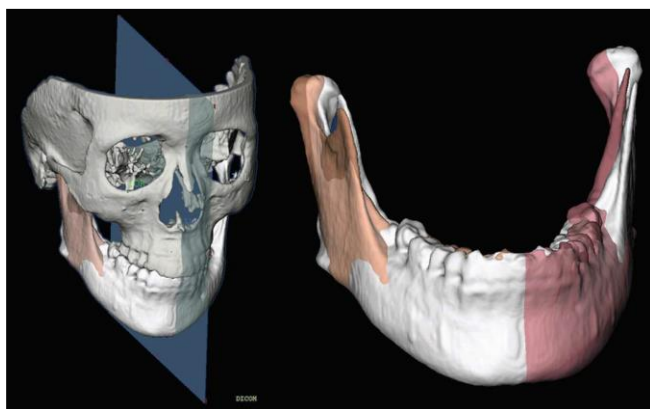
CBCT of facial asymmetry
